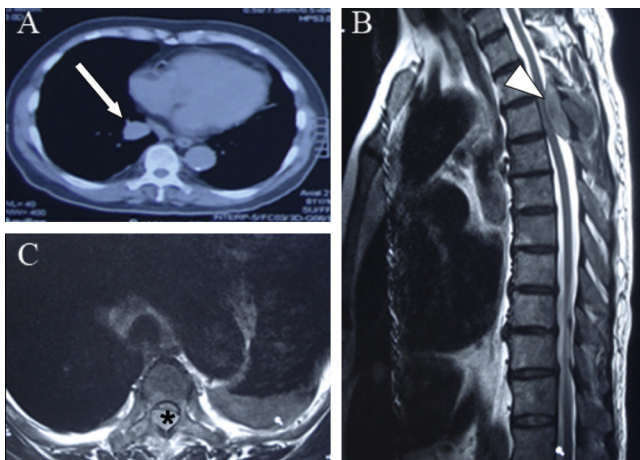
(A-C) CT and MRI images of the patient at the diagnosis of HPS. CT image (A) showed a metastatic lesion (arrow) in the right lung on mediastinal window. T2-weighted images (B-C) showed epidural mass lesion (arrow) at T4 level with compression of the spinal cord (asterisk)
